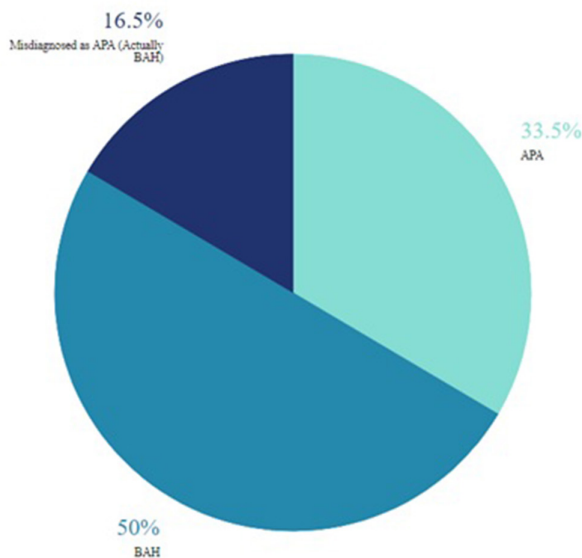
Pie chart of CT managed diagnosis of PA. Assuming 33% of the CT diagnosed APA is incorrect,¹⁹ CT diagnoses APA in 33.5% and BAH in 66.5% of the PA cases. APA, aldosterone-producing adenoma; BAH, bilateral adrenal hyperplasia; PA, primary aldosteronism.
